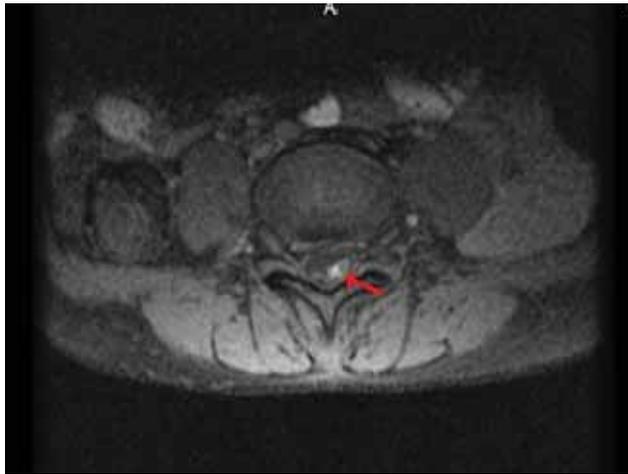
Axial T1 lumbar spine MRI; hyperintense signal corresponding to contrast enhancement of cauda equina
